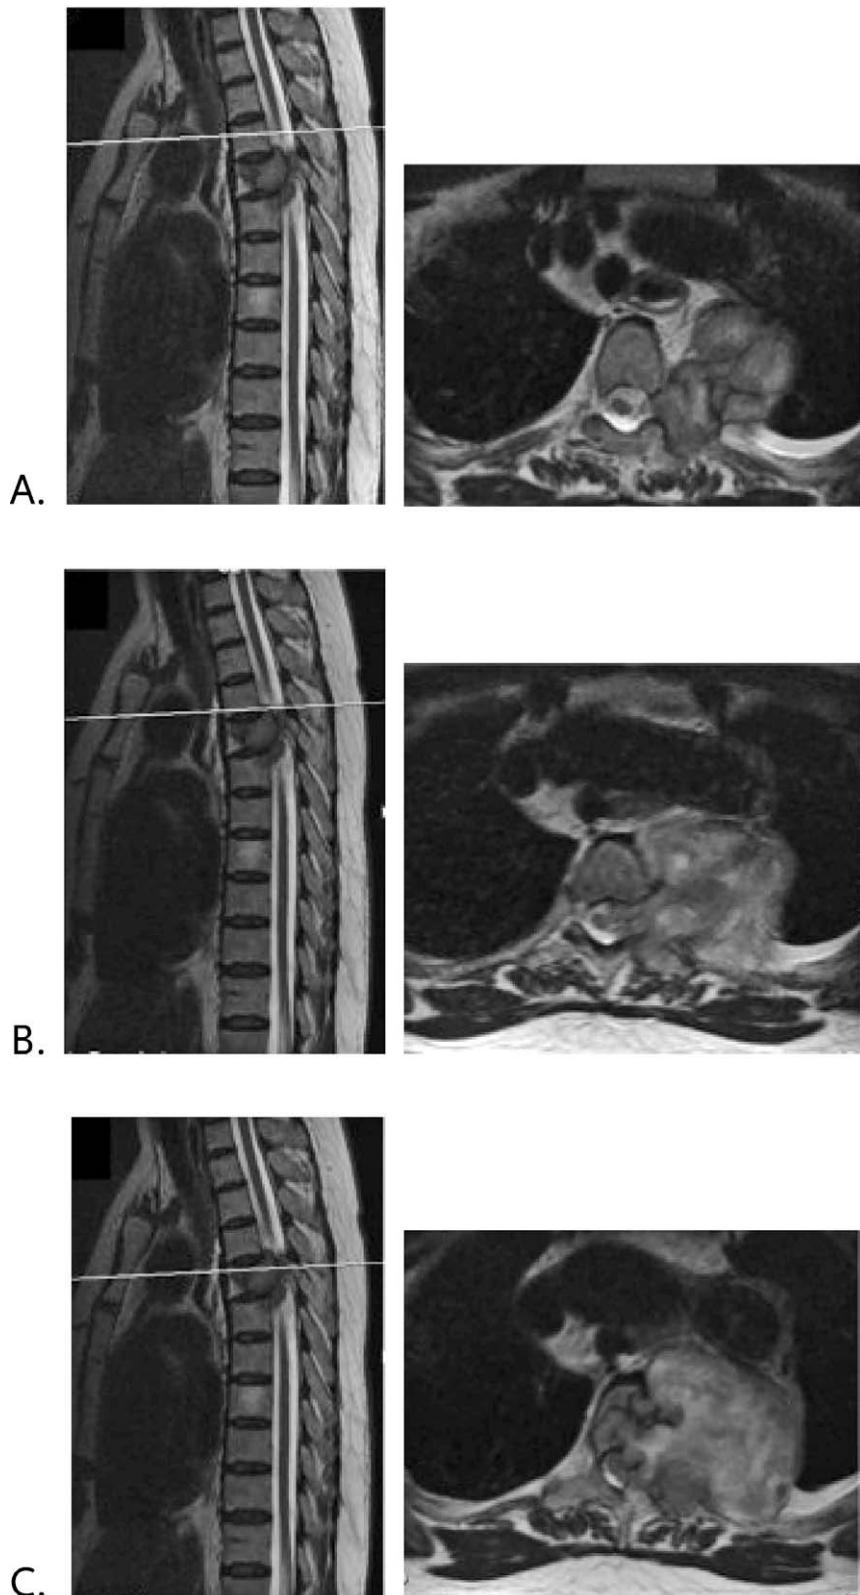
Magnetic resonance imaging T2-weighted noncontrast of giant invasive thoracic schwannoma from cephalad to caudal. A, B: T3 vertebral body slices; the tumor widens the left foramen and left-sided lamina. C, D: T4 vertebral body slices; the tumor erodes the vertebral body, widens the foramen, and erodes the left-sided lamina and rib, invading the myofascial plane. The spinal cord has lost its shape, but cerebrospinal fluid signal is still seen around it. The descending aorta is pushed anteriorly by the mass effect of the tumor. E: T5 vertebral body slice; the tumor erodes part of the vertebral body and left-sided pedicle.
